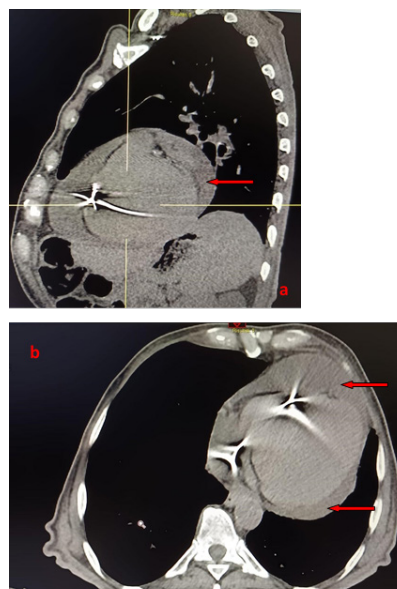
(a-b): MPR CT reconstructions showed the presence of a large pericardial effusion (4cm), antero-lateral and apical (red arrow), and the presence of cardiac Pace-Maker.
